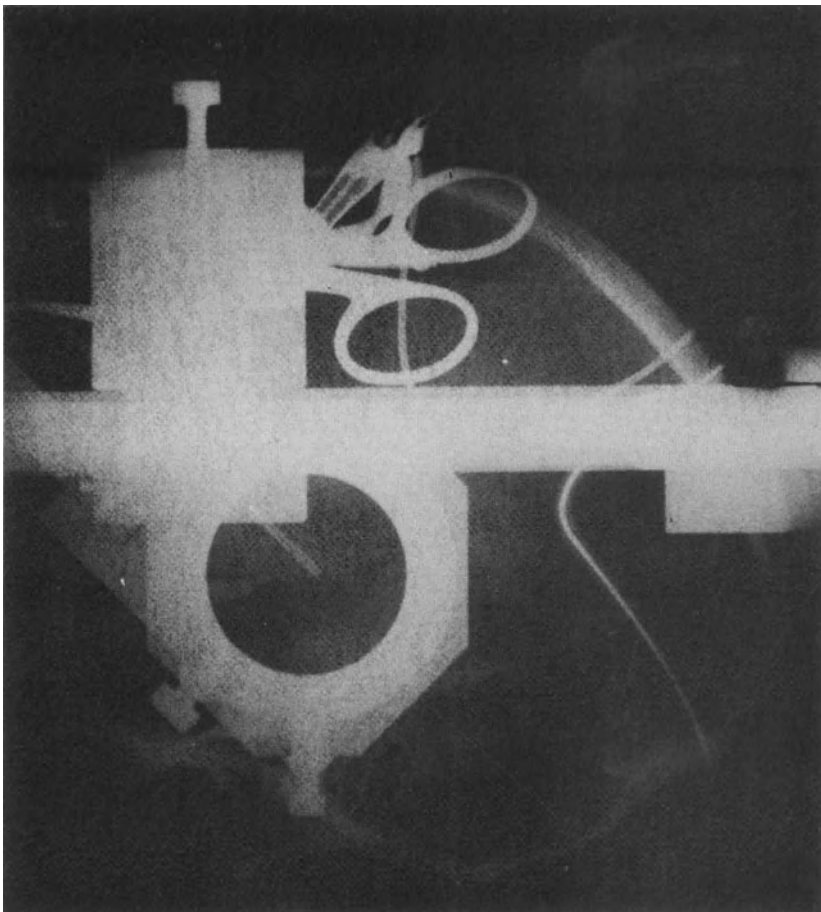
Roentgenogram shows position of target electrode.
